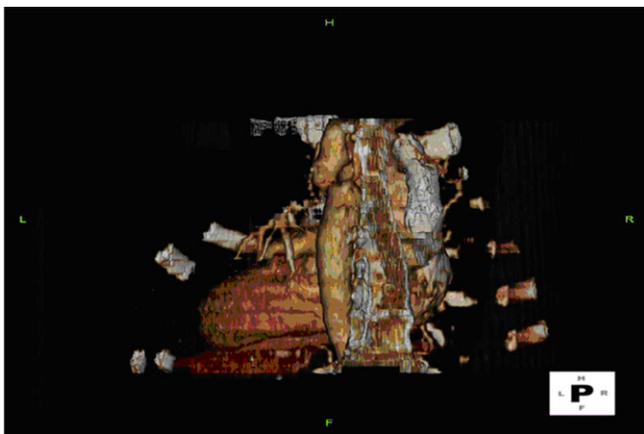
Pre-operative CT angiogram displaying a postductal aortic coarctation with a true lumen measuring 2 mm approximately 1 cm distal to the origin of the left subclavian.
